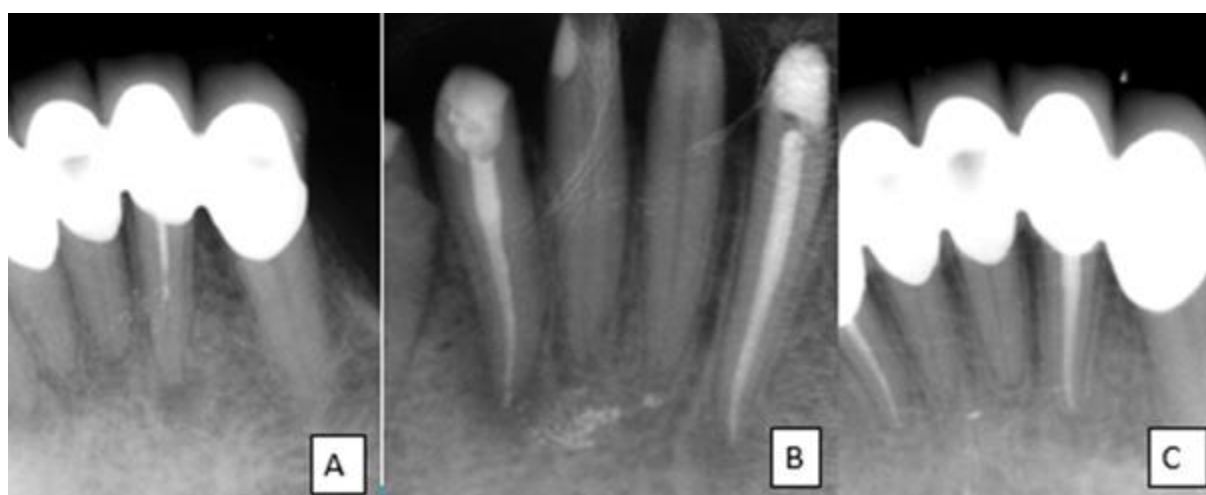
Periapical radiographs of tooth #22 in a healthy patient. (A) Preoperative, (B) postoperative, and (C) twenty-two-month follow-up radiographs.
